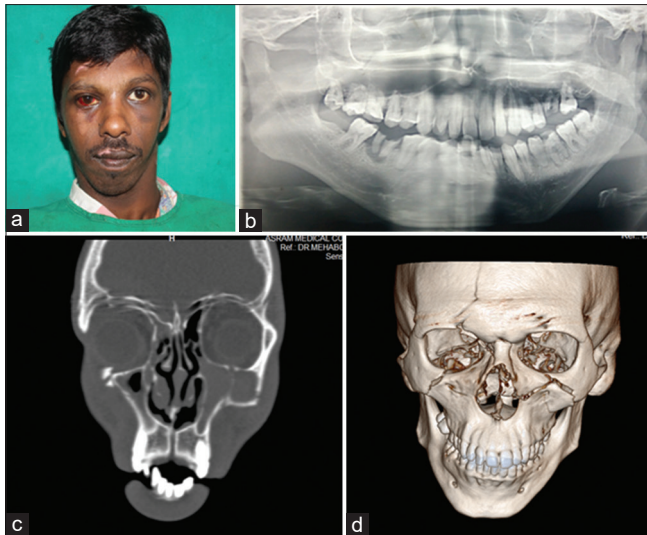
(a) Pre-operative profile, (b) Conventional radiograph, (c) multidetector computed tomography (MDCT), (d) 3D MDCT
